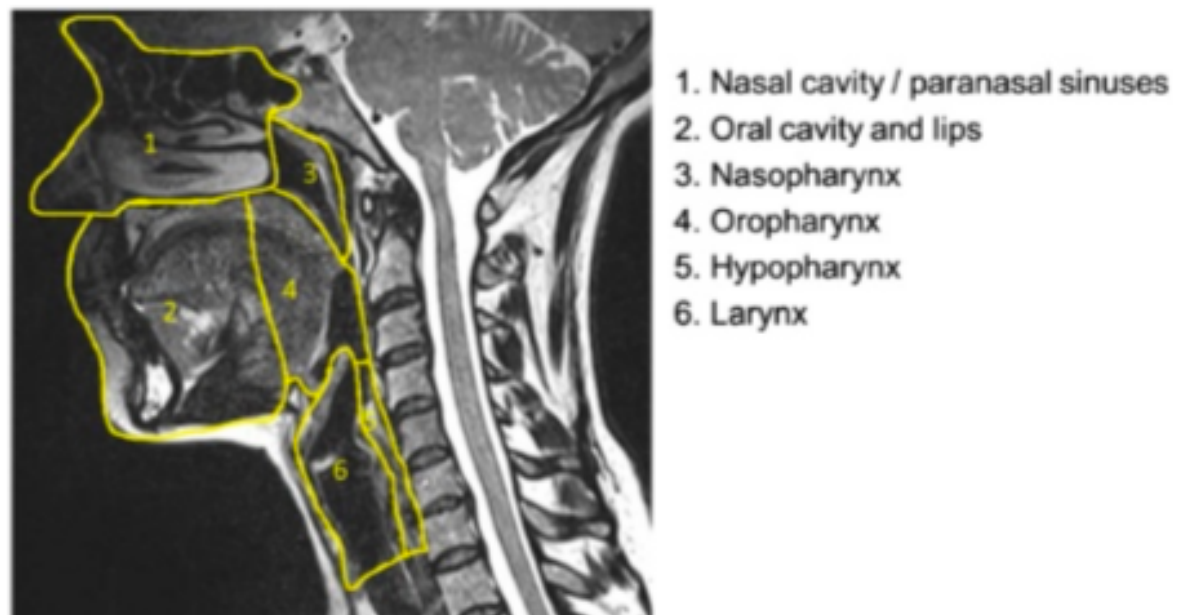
Radiological anatomy of head and neck – CT image
